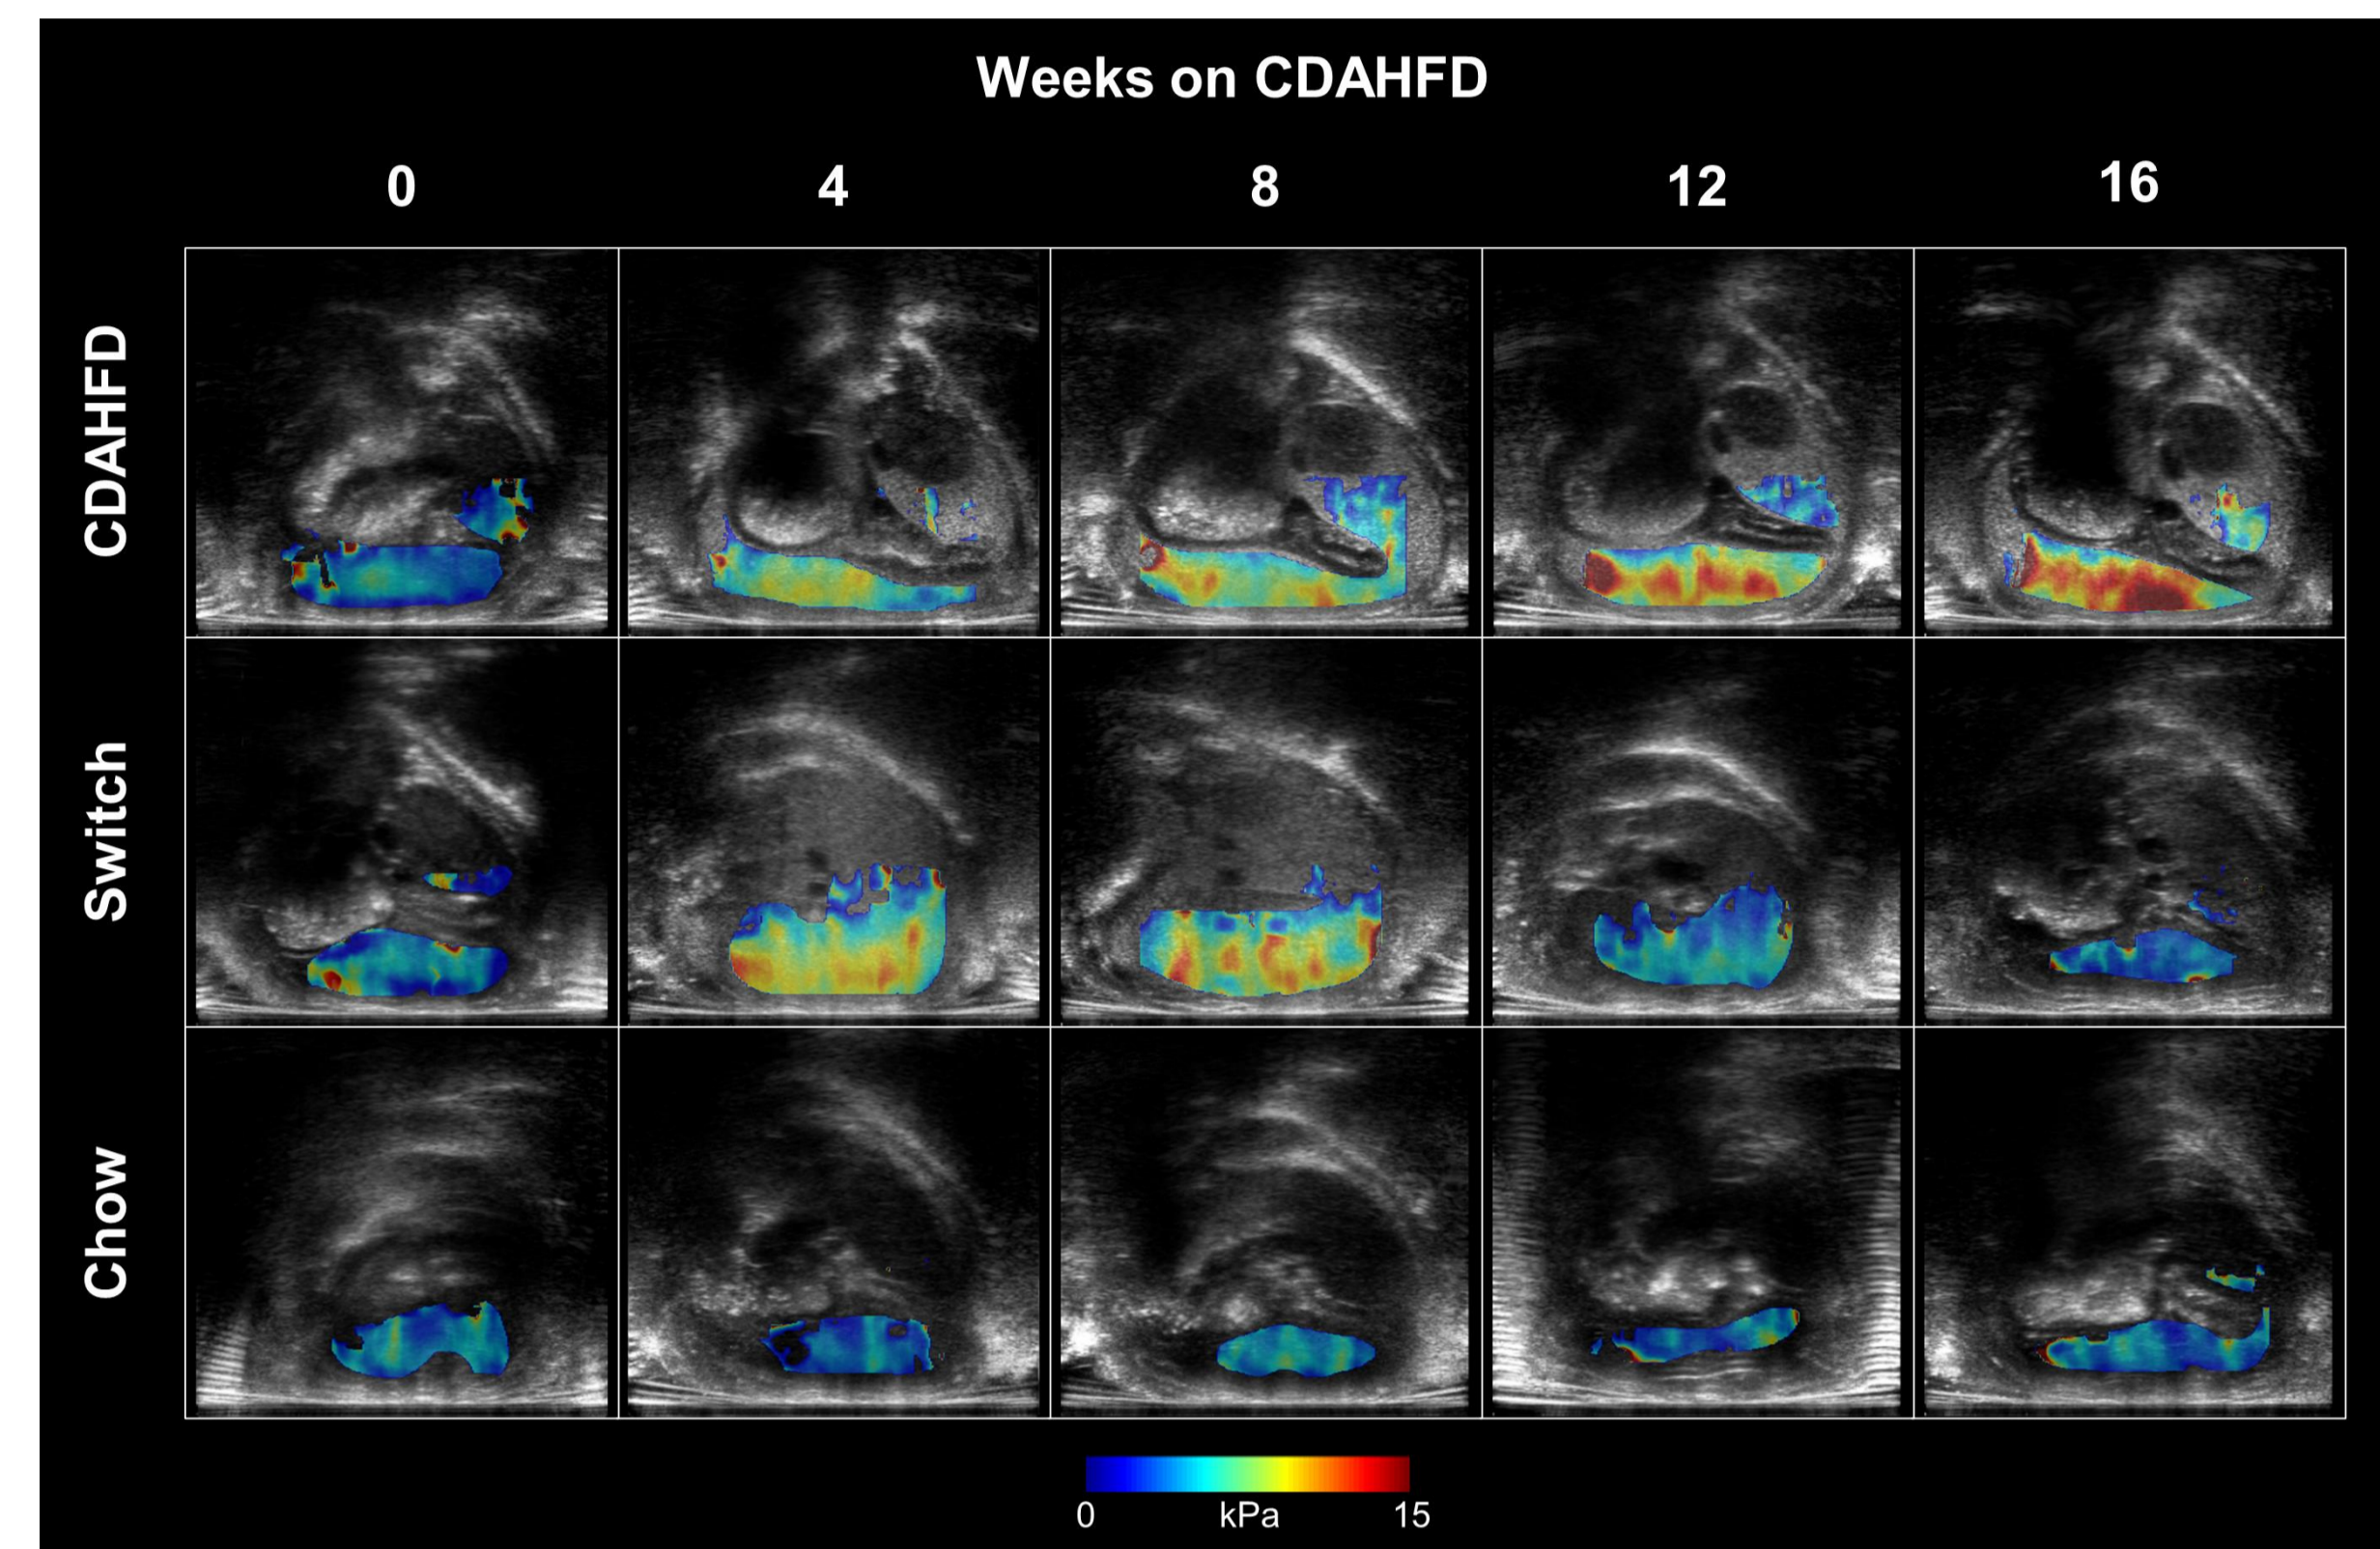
Representative longitudinal liver ultrasound images (axial plane) in the three different groups across the course of the CDAHFD diet-reversal study. Shear wave elastography (SWE) scans are overlaid on grayscale B-mode images. CDAHFD elicited a strong response in noninvasive markers of liver echogenicity, stiffness, and volume, with clear reversal at the diet switch timepoint (8 wks).
